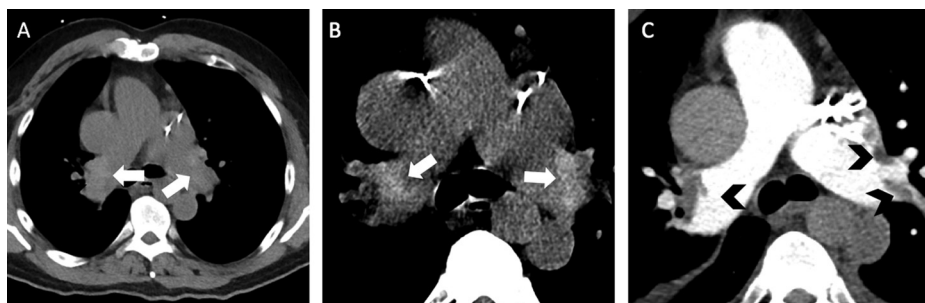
49-year-old man with central pulmonary embolism. Unenhanced chest CT images (120 kV 136 mAs) in the transverse plane with A, standard (Level, 40; Window width, 350) and B, narrowed (Level, 60; Window width, 120) windows demonstrate spontaneously hyperattenuating foci (arrows) within proximal pulmonary arteries. C. At day 5, follow-up contrast-enhanced chest CT image confirms bilateral thrombi (arrowheads) within proximal portion of pulmonary arteries.
